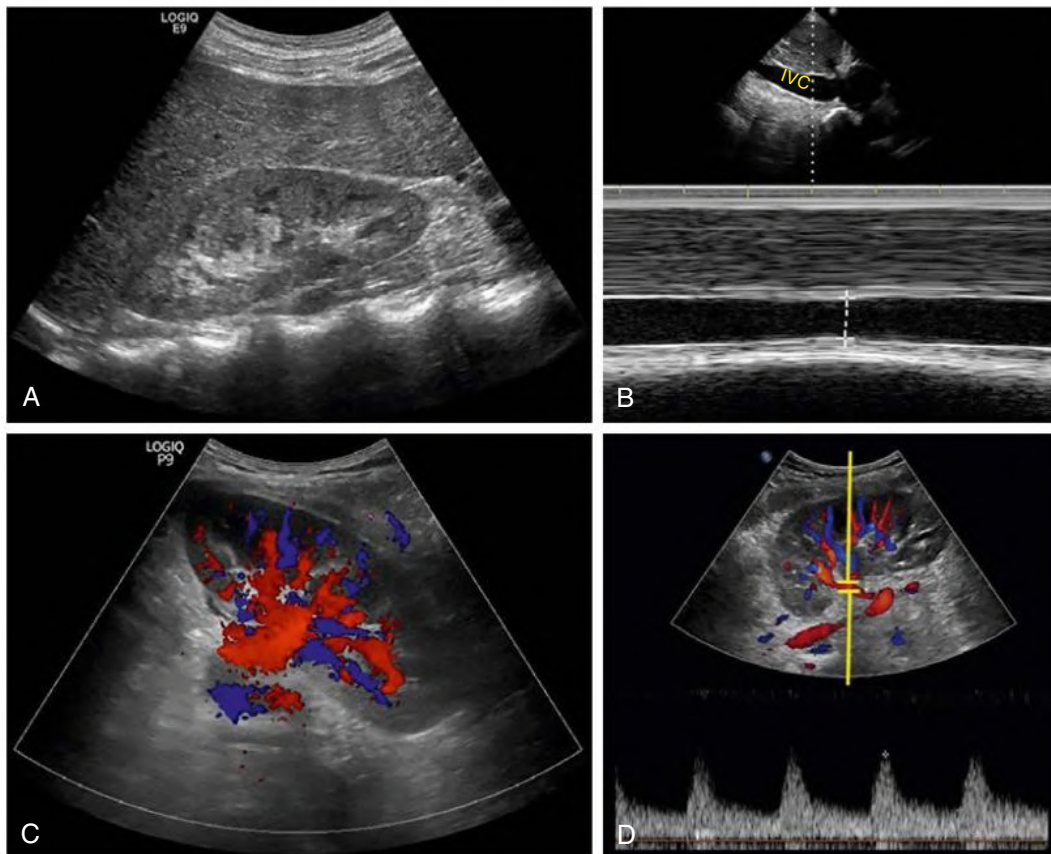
(A) Grayscale image of a normal kidney. (B) M-mode image of the inferior vena cava. Tracing represents movement of the structure over time along the cursor (*dotted line*). (C) Color Doppler image of a normal transplanted kidney. (D) Pulsed wave Doppler image of renal artery. Note the Doppler line, which is like the M-mode cursor but with a small opening called sample volume, which should be placed in the region of interest to measure the flow. (Created with Biorender.com.)
